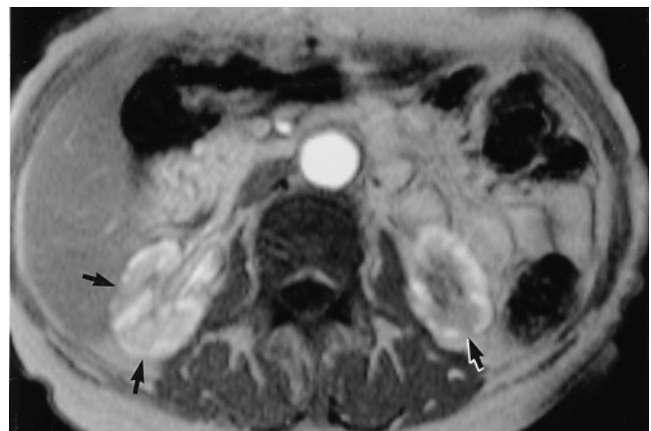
Tubulointerstitial disease secondary to analgesic abuse. T1-weighted immediate postgadolinium SGE image demonstrates irregular cortical thinning ranging in thickness from 1 to 4 mm. Regions of extreme cortical thinning are apparent (arrows) (Reproduced with permission from Kettritz U, Semelka RC, Brown ED, Sharp TJ, Lawing WL, Colindres RE: MR findings in diffuse renal parenchymal disease. *J Magn Reson Imaging* 6: 136-144, 1996.)
